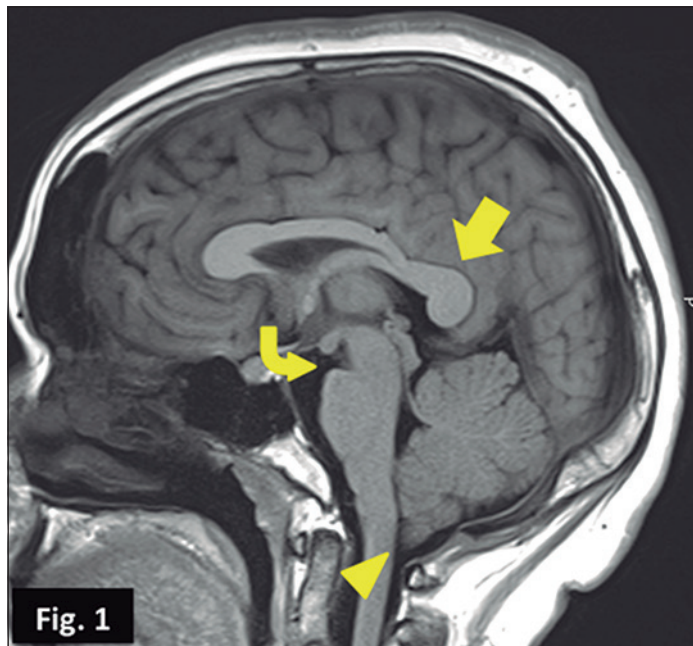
Magnetic Resonance Imaging (MRI) of the brain in sagittal T1 sequence without contrast. Signs of endocranial hypotension characterized by caudal angulation of the posterior third of the corpus callosum (arrow) and descent of the cerebellar tonsils (arrowhead) are recognized. Subtle caudal displacement of the brainstem (curved arrow) is also observed.
